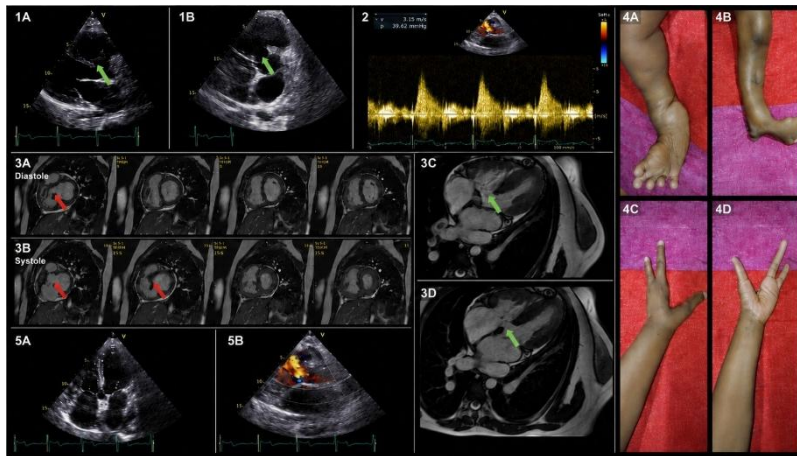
Multimodality imaging of a double-chambered right ventricle with associated congenital anomalies. 1A-B: TTE reveals anomalous muscular bundles dividing the right ventricle. 2: Continuous-wave Doppler demonstrates significant intraventricular obstruction with flow acceleration. 3A-D: Cardiac MRI confirms right ventricular subdivision and delineates the obstructive anatomy. 4A-D: Limb malformations raise suspicion for an associated syndromic condition. 5A-B: Subcostal color Doppler imaging demonstrates an atrial septal defect.
